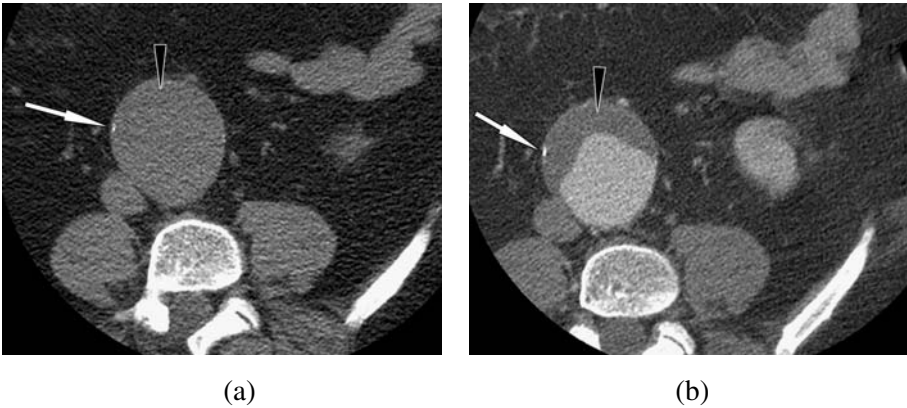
Axial CT images of atherosclerotic intraluminal thrombus in abdominal aortic aneurysm demonstrate intima calcification at the outside of the thrombus (white arrow): (a) unenhanced image shows low attenuation of the intraluminal thrombus (black arrowhead), which cannot be distinguished from the perfused lumen of the aorta; (b) contrast enhanced image delineates the intraluminal thrombus (black arrowhead), which shows low attenuation compared to the contrast enhanced lumen of the aorta. This example of intraluminal thrombus is relatively smoothly demarcated and could be confused with IMH on the contrast enhanced scan; however, low attenuation on the unenhanced scan excludes acute IMH.
